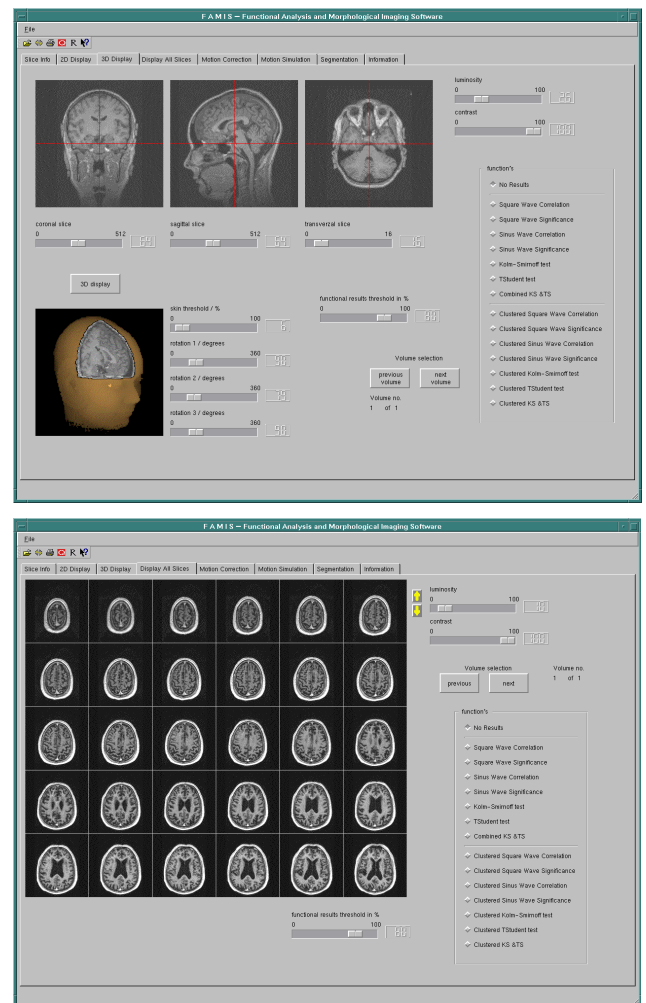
3D representation (upper image) and stamp representation (lower image) of morphological MRI-data.
